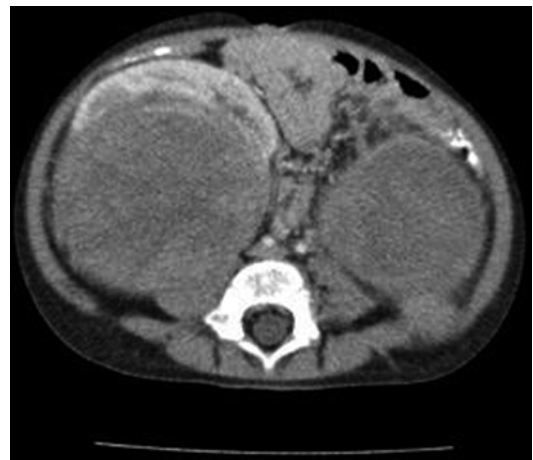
A computed tomography scan demonstrating the typical appear of a bilateral Wilms' tumor
